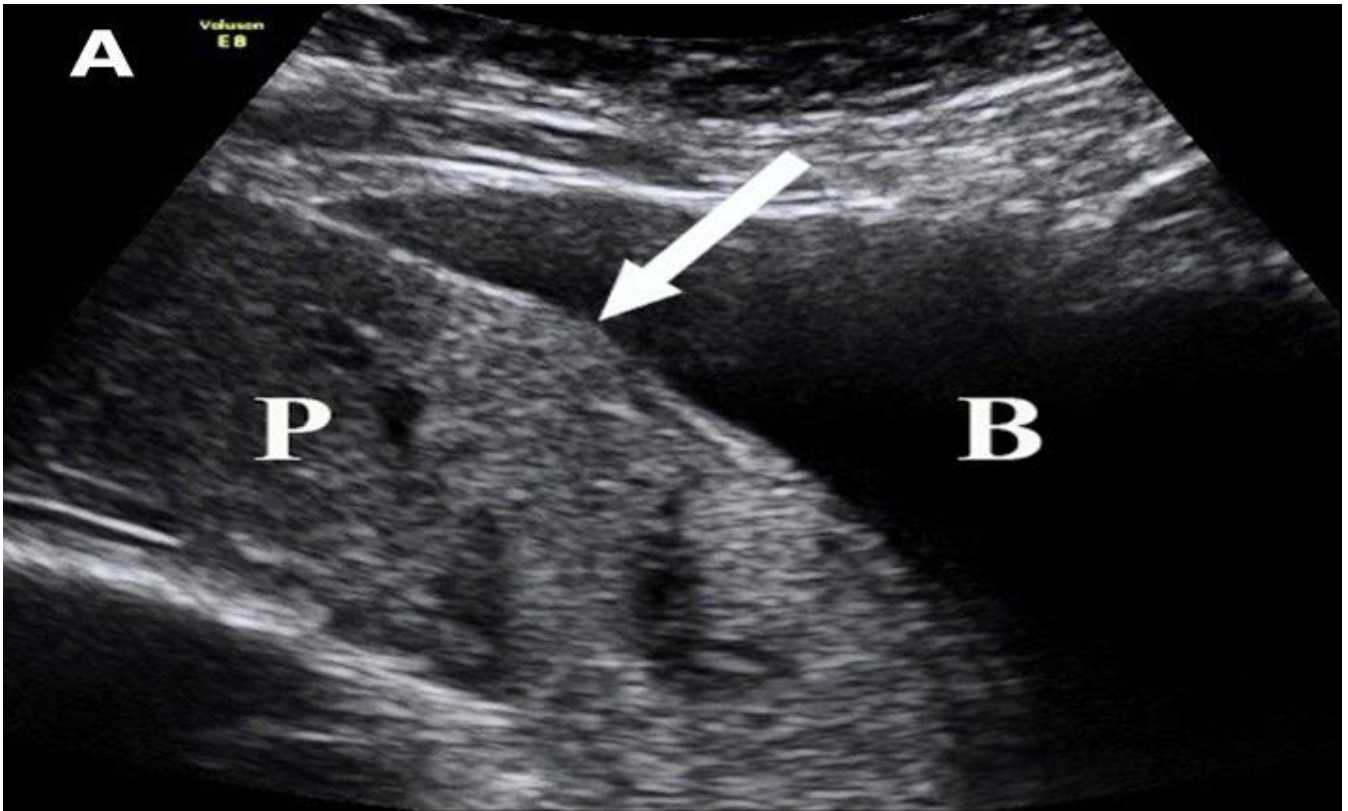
Myometrial thinning secondary to uterine thinning at scar defect. A, Transabdominal ultrasound longitudinal view of placenta (P) previa at 36 weeks showing myometrium defect (arrow) under bladder (B). Note absence of clear zone and myometrium in area (B) [26].
